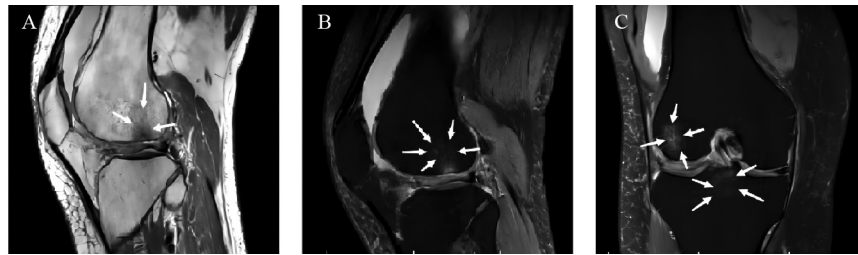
Magnetic resonance imaging (MRI) of knee OA in a 62-year-old female. (A) Sagittal T1-weighted image shows diffuse bone-marrow edema at the distal end of the femur, presenting as low signal (white arrows). (B) Sagittal T2 intermediate-weighted fat-suppressed image shows the same lesion in the distal femur (white arrows). (C) Coronal fat-suppressed proton density (PD) MRI shows bone-marrow edema at the load-bearing site of the medial condyle of the femur and below the insertion point of the proximal cruciate ligament of the tibia (white arrows).
